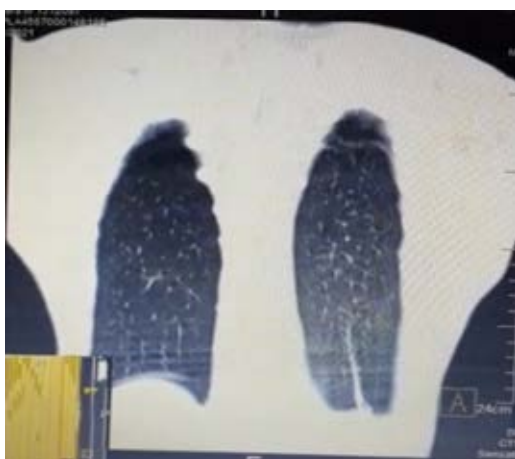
A thorax computed tomography scan showing a left pulmonary bulla.
